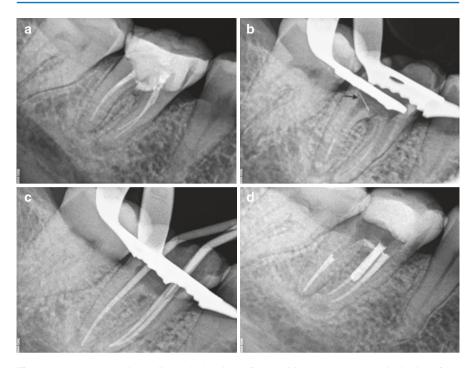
(a) Preoperative radiograph showing a fractured instrument at the apical third of the mesiobuccal root canal of tooth #46 with a diagnosis of chronic apical periodontitis. (b) A staging platform was created around the most coronal aspects of the fragments by using modified Gates Glidden drills (#2–4). Thereafter, an RT3 (EMS) ultrasonic tip was activated at low power settings, which trephined dentin in a counterclockwise motion around the fragments. With this action and the vibration being transmitted to the fragments, the fragment began to loosen. At this stage, it was bypassed with size #10 up to size -25K-files and "washed out" (*arrow*) to the floor of the pulp chamber with the irrigant. (c) Master cone radiograph. (d) Final radiograph showing complete obturation of the root canal and temporary restoration with a cotton pellet and Cavit (Courtesy of Dr. T. Zarra)
